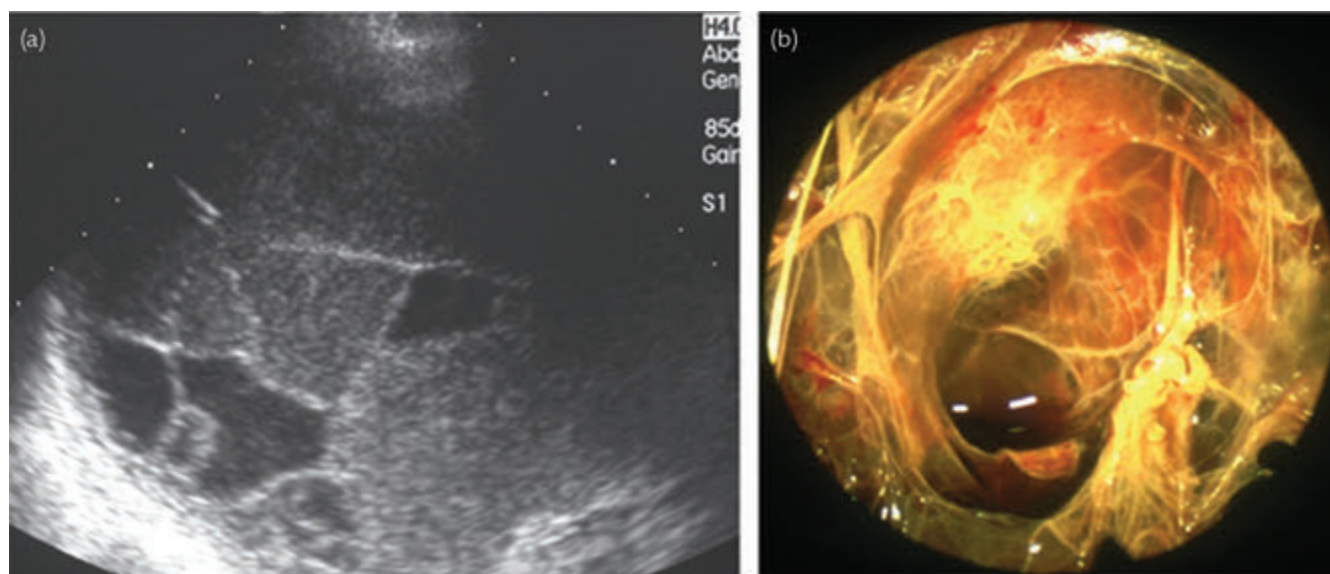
Fibrinous septations due to pleural infection shown on ultrasonography (a) and directly observed at thoracoscopy (panel b).
